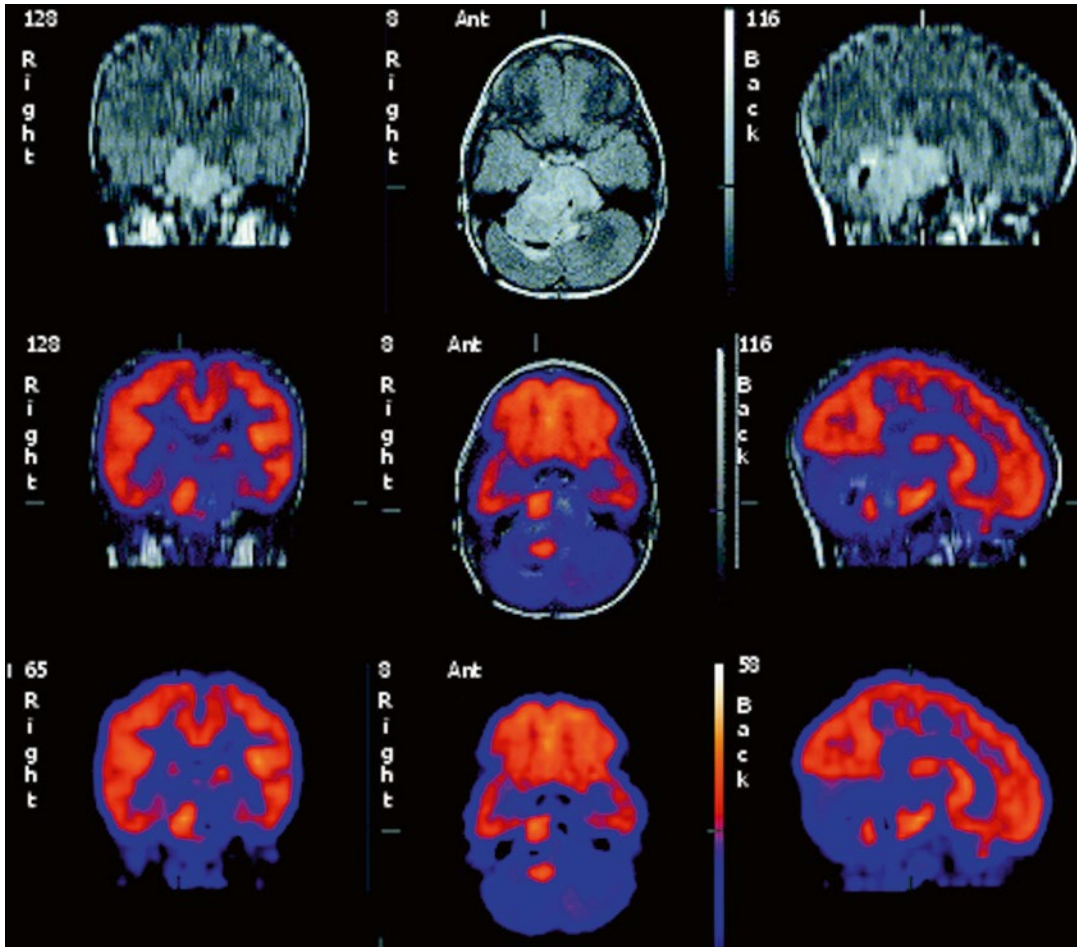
Large brain tumor well seen on the MRI. Within the large tumor, there are two distinct foci of ^{18}F -FDG uptake that may indicate active residual tumor
